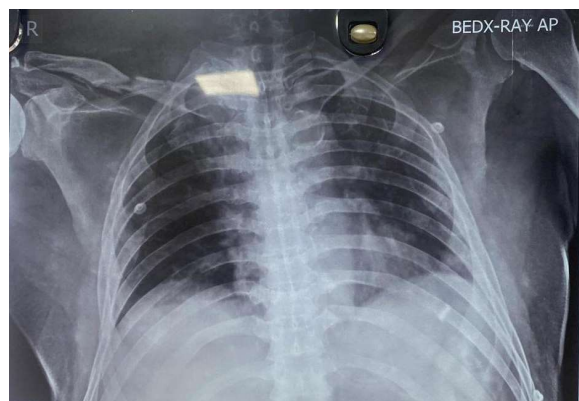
Pre operative Xray of 1st surgery
